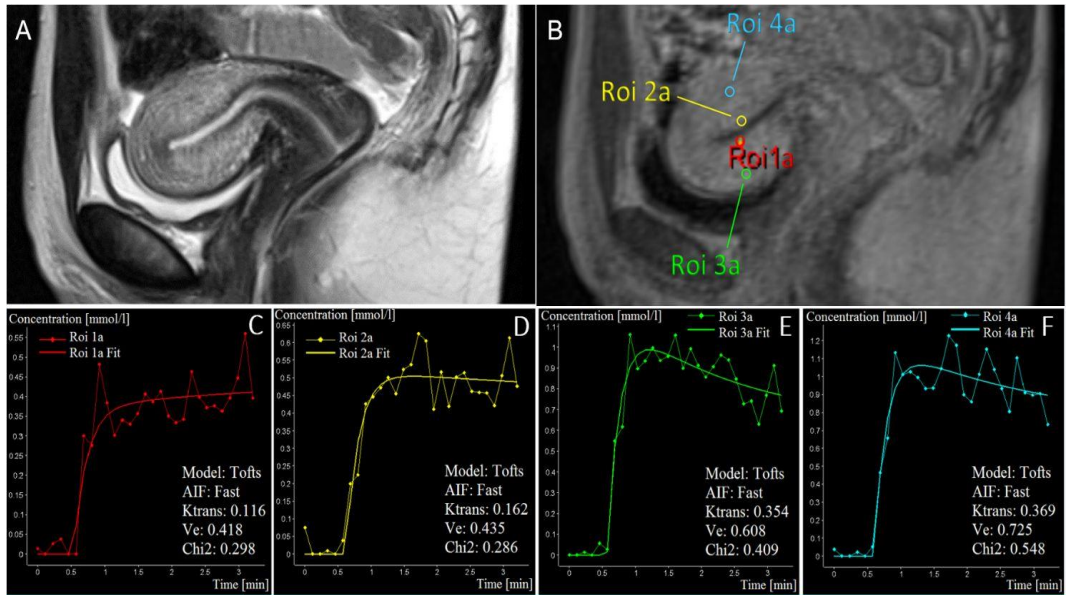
Example of perfusion assessment by dynamic contrast-enhanced magnetic resonance imaging (DCE-MRI) in the corpus and cervix uteri. A: Sagittal T₂-weighted pelvic MRI-scan. B: Dynamic MRI-scan in order to assess perfusion Tissue 4D Calculations in different locations. The Regions of Interests (ROI's) were placed at the anterior wall of the junctional zone (ROI 1a), at the posterior wall of the junctional zone (ROI 2a), at the anterior wall of the outer myometrium (ROI 3a), at the posterior wall of the outer myometrium (ROI 4a), at the anterior wall of the inner third of the cervical stroma (ROI 1b), at the posterior wall of the inner third of the cervical stroma (ROI 2b), at the anterior wall of the outer two-thirds of the cervical stroma (ROI 3b) and at the posterior wall of the outer two-thirds of the cervical stroma (ROI 4b). C-J: Examples of concentration-time curves for respectively each ROI.
